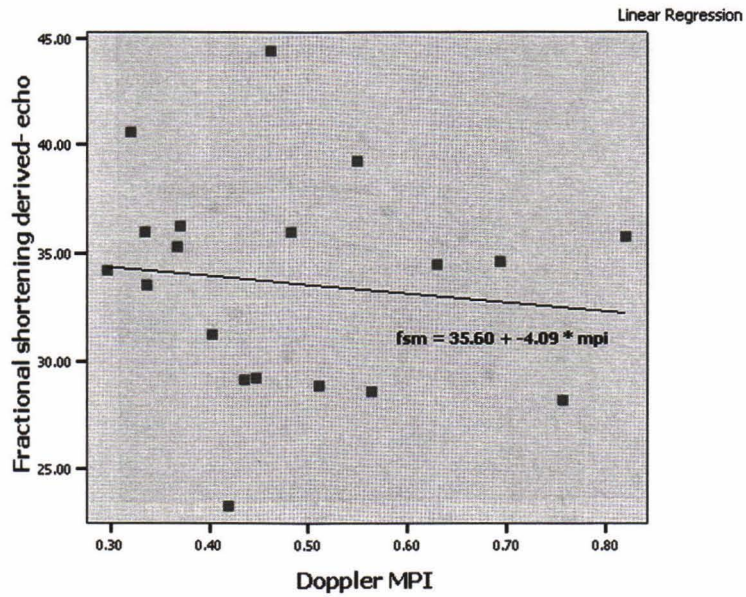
Correlation between Doppler myocardial performance index (MPI) and echocardiographic derived fractional shortening (FS).
